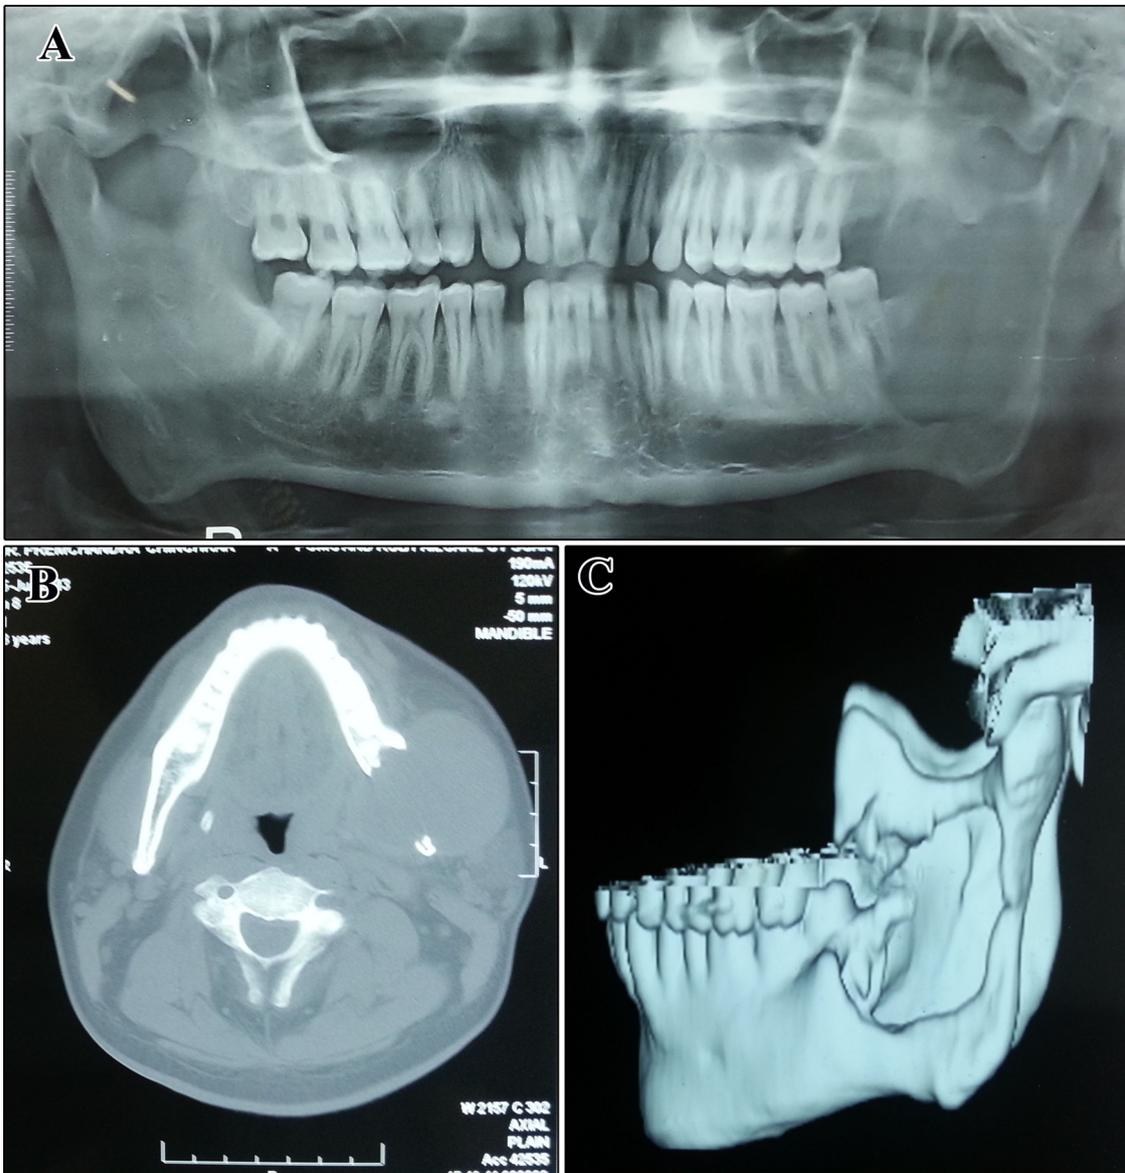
Orthopantomogram showing large unilocular lesion involving ramus of the left side of mandible (A). The computed tomography revealed large osteolytic lesion with destruction of cortical plates (B and C).
